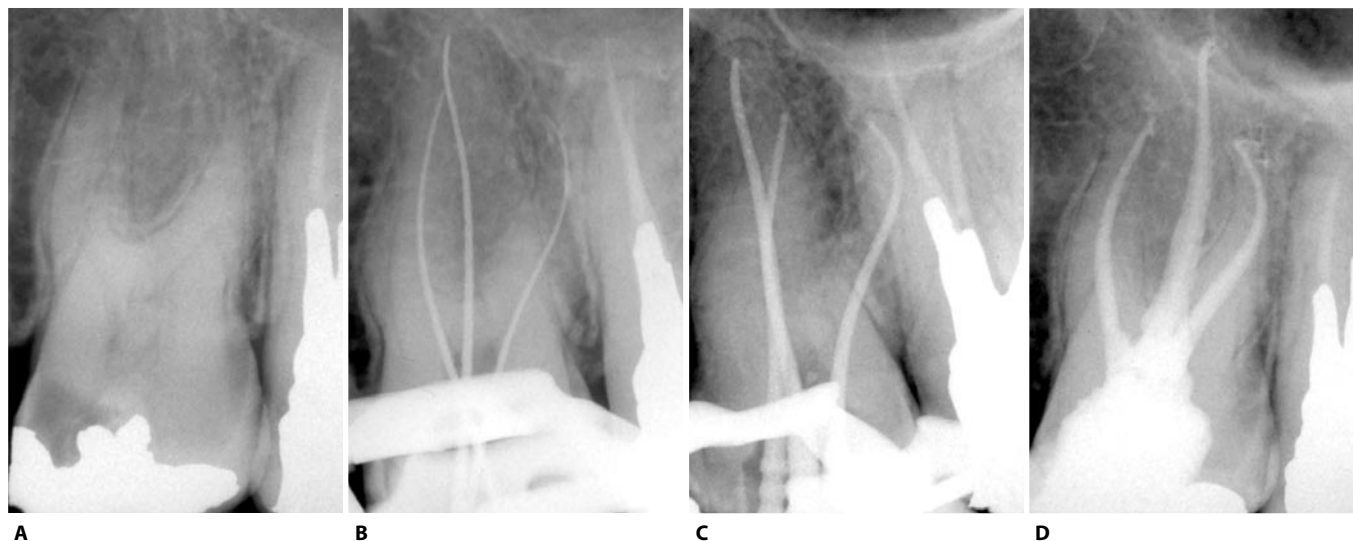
To correctly carry out a Thermafil obturation at least four radiographs are required. A, B. Diagnostic and working length determination. C. Plastic verifier radiograph. D. Post-operative radiograph.
